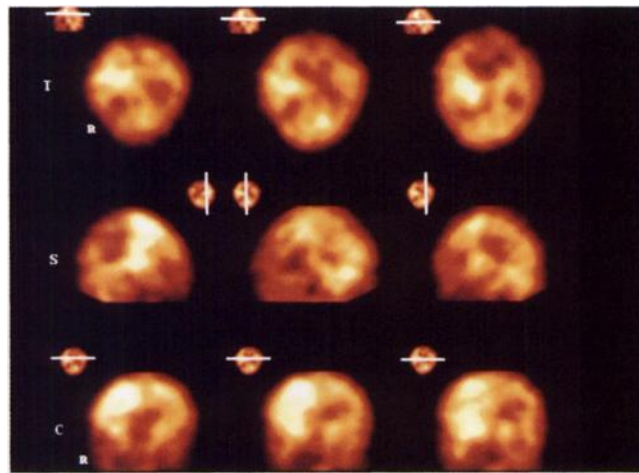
Diffuse decrease in rCBF in contralateral hemisphere (Patient 11). Contralateral hemispheric abnormality may be related to high flow state at the time of the right common carotid artery ligation for ECMO. MRI the day before and MRA the day after SPECT were normal.
